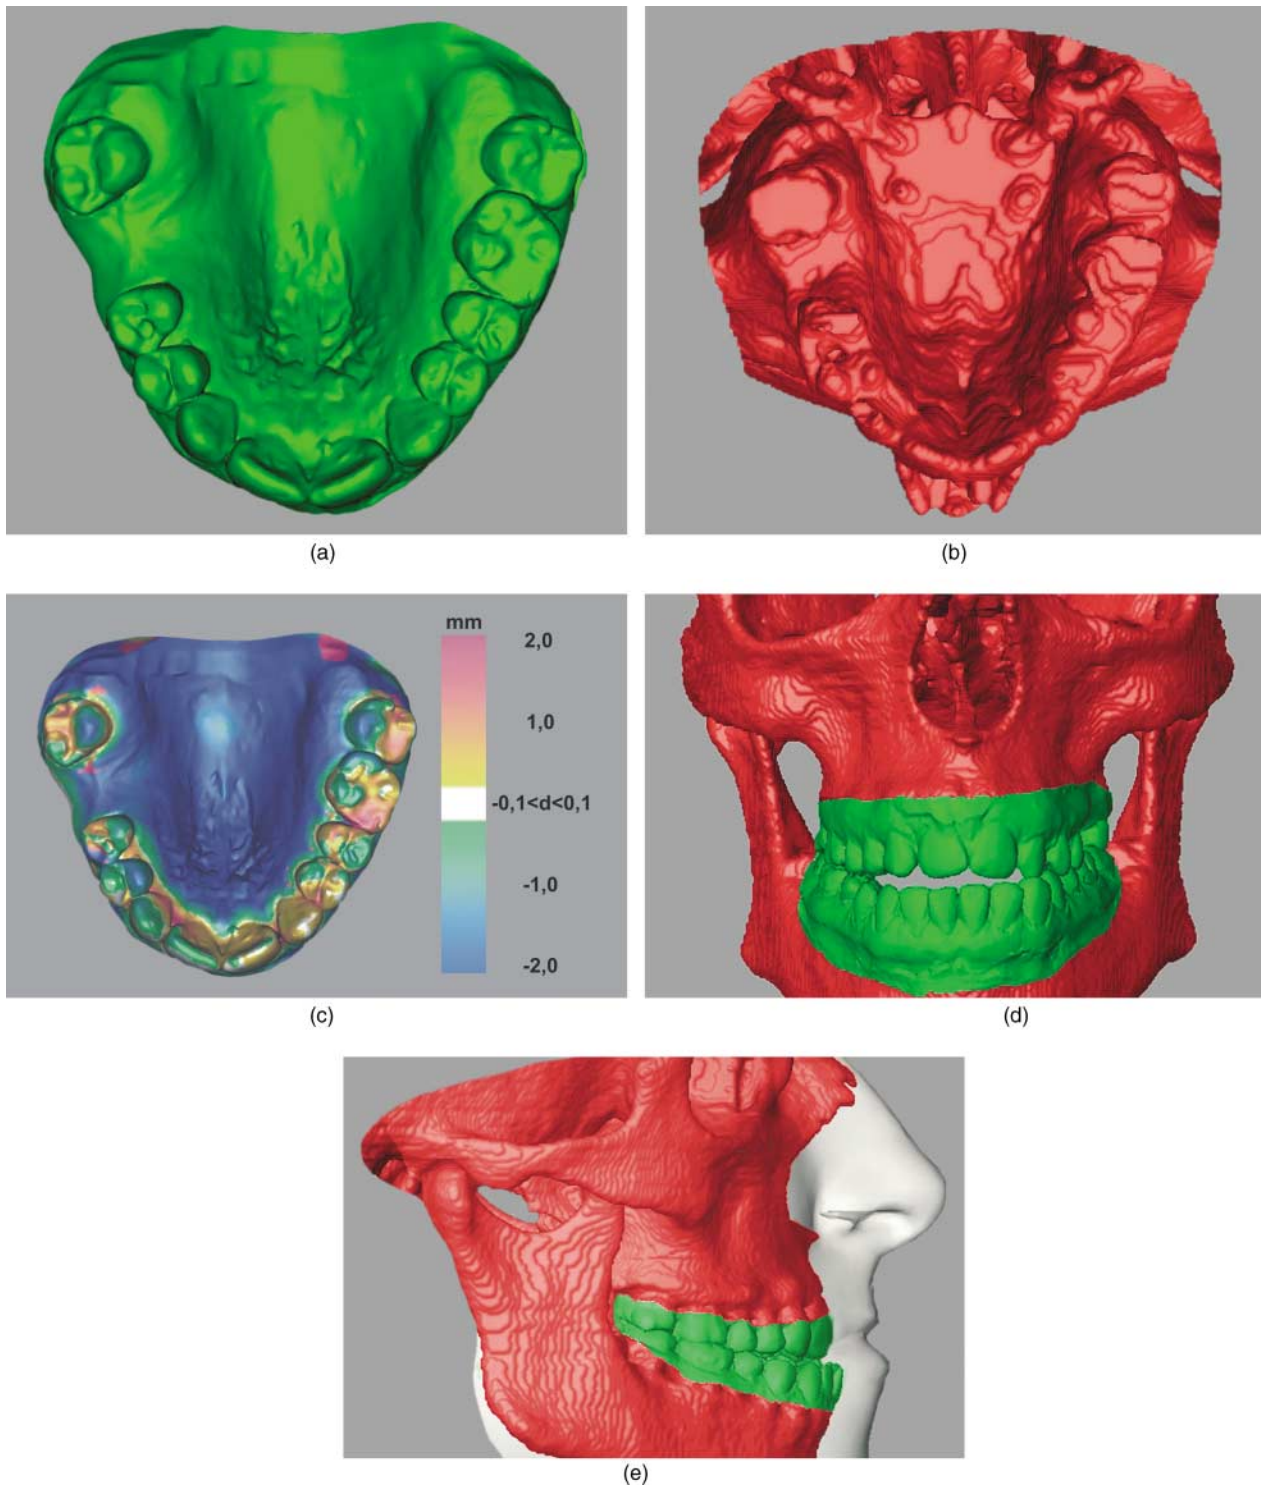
(a) Optical surface data of the patient's maxilla. (b) Isosurface of the maxilla generated from the CT scan after streak artefact correction. (c) Colour-coded visualization of the differences between CT and optical data of the maxilla after the registration procedure. (d) *En face* situation of the registered, pre-operative CT (red) and optical data (green). (e) Profile situation of the registered, pre-operative CT (red) and optical data (green), with overlying soft tissue
